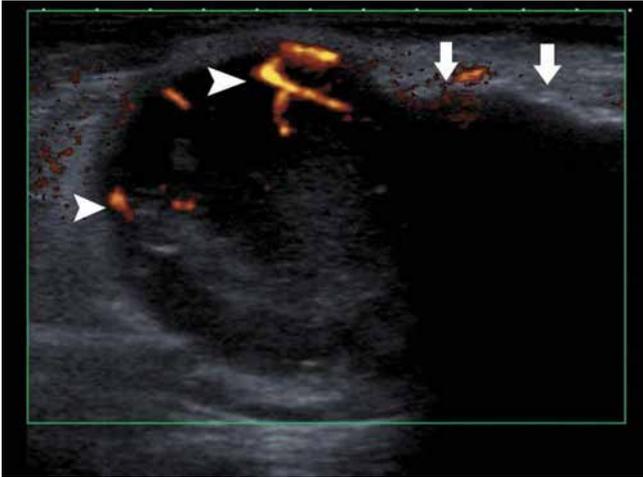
Ultrasound of the groins showing enlarged inguinal lymph nodes with calcified areas demonstrating retroacoustic shadowing (white arrows). The noncalcified solid parts are hypoechoic with foci of increased Doppler flow (white arrowheads).
